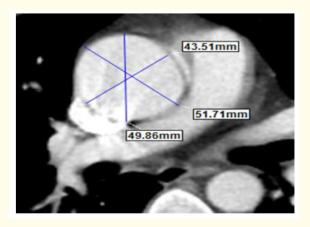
Chest CT-Scan showed dilated ascending aorta.
